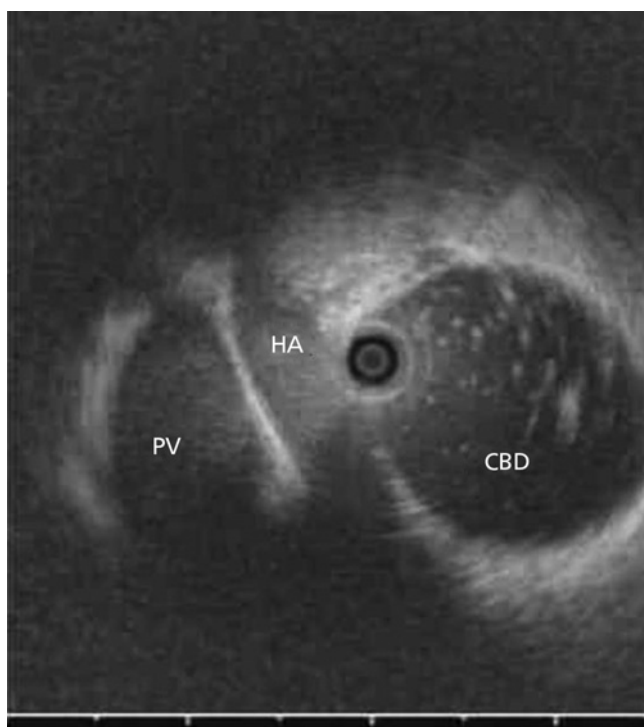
Intraductal ultrasound (Olympus America, Inc, Center Valley, PA) image showing suspended sludge in the dilated common bile duct (CBD) with a normal wall. Also seen are the hepatic artery (HA) and the portal vein (PV) to complete the portal triad.
